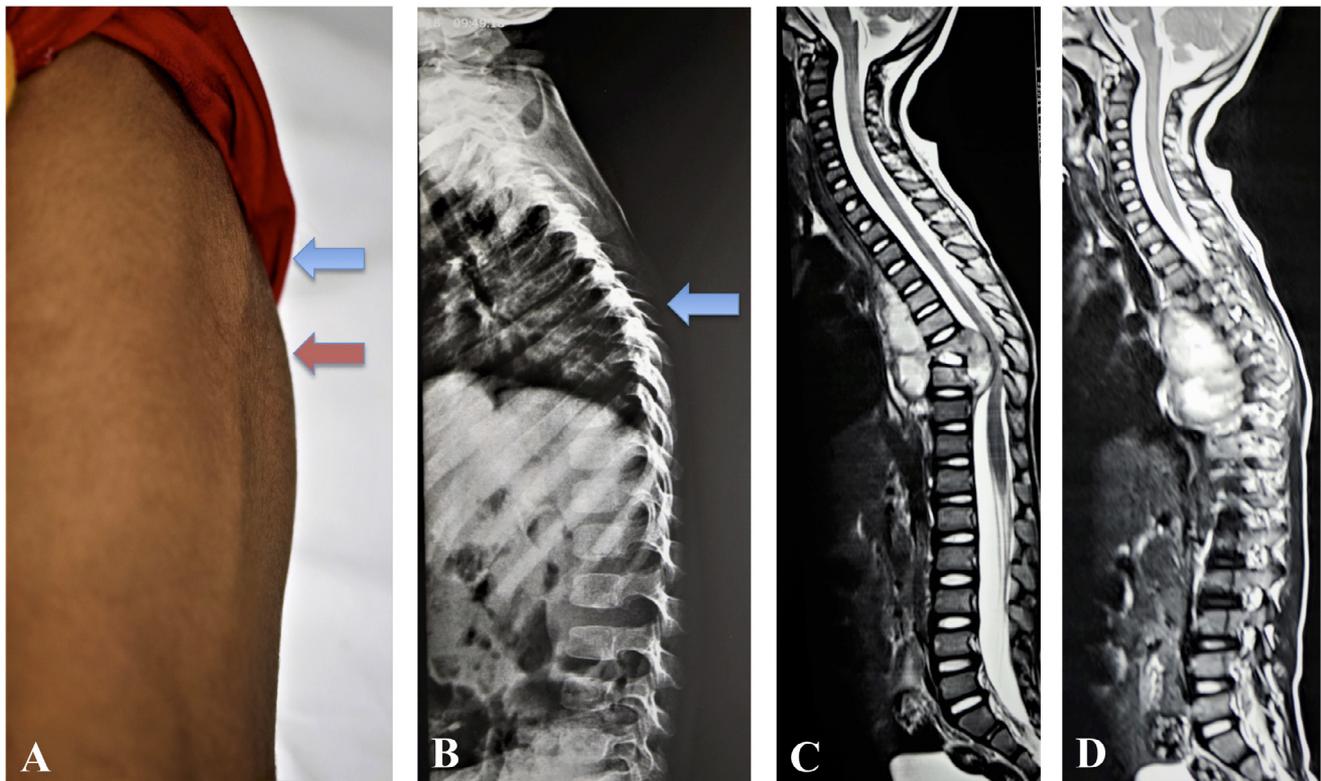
(A) is a clinical image of a subtle gibbous deformity in the mid thoracic spine of a 5-year-old boy with back pain (blue arrow), with a concavity just caudal to the gibbous suggesting a compensatory lordosis (orange arrow). (B) is a lateral spine radiograph showing very large para-spinal shadow at the mid to lower thoracic spine (blue arrow). (C) is the central sagittal cut of the patient's full spine MRI. (D) is the para-central cut. There is destruction and collapse of the T8 vertebra, with some end plate destruction of the caudal end plate, intact intervertebral disc space and decreased T9 vertebral height. There is signal change in both of these vertebrae with a large prevertebral, subligamentous, epidural, and para-spinal collection. The epidural collection is indenting the cord. Clinical images courtesy of Dr. Mathew Varghese MS.
